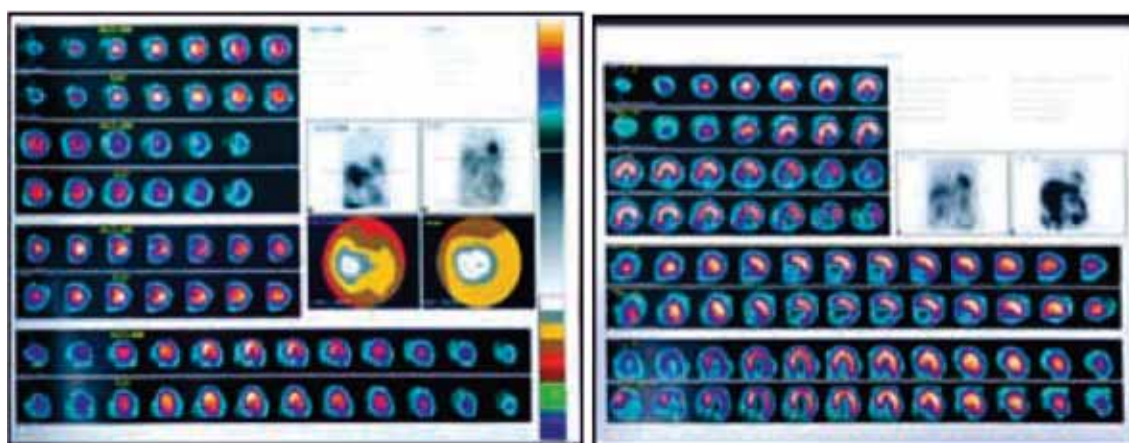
Two cardiac studies (Rest-Stress on 18/12/2021 for ischemia evaluation and rest only for viability assessment on 20/12/2021) using GE Discovery 670DR SPECT-CT scanner in patients for suspected coronary artery disease evaluation: A comparison between $^{201}\text{TlCl}$ vs $^{99\text{m}}\text{Tc-MIBI}$ performed on same patients.
